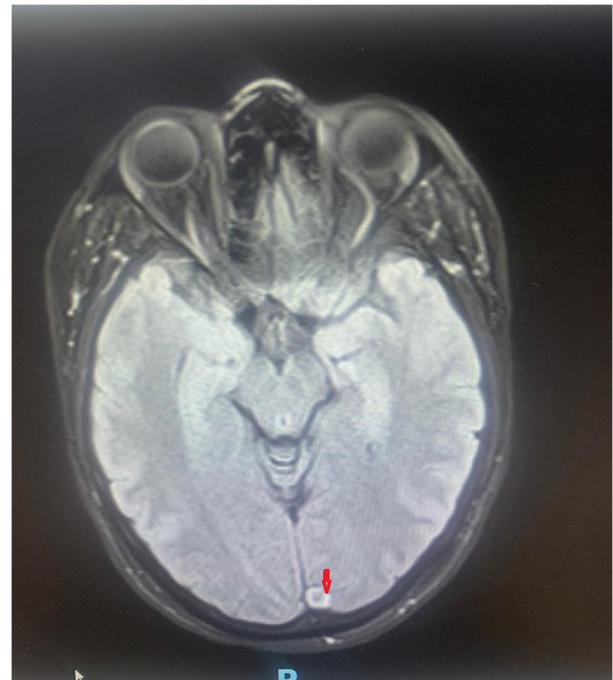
MRI FLAIR sequence axial section. The arrow shows loss of normal flow void. Image was obtained in June 2023.
